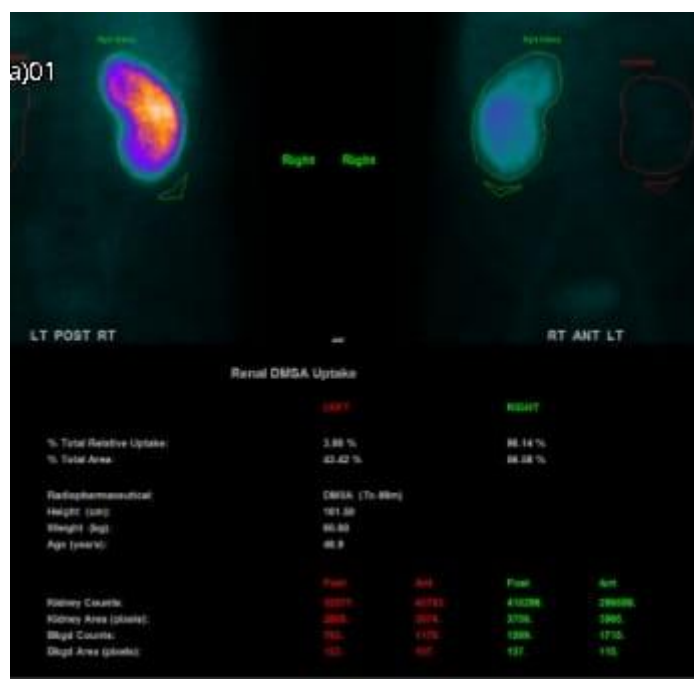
DMSA renal scintigraphy showing preserved right renal cortical uptake and markedly reduced left renal function.
